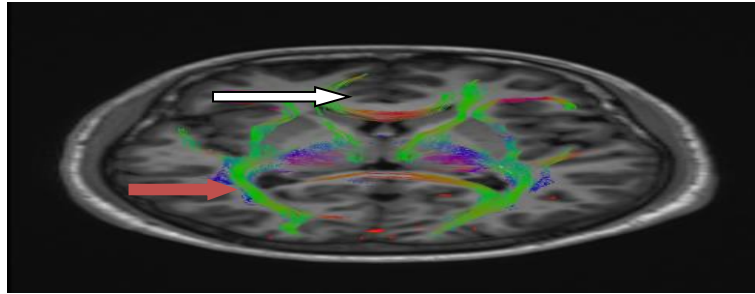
Axial MRI DTI images of the same patient at the level of internal capsule reveals normal fibers of internal capsule (White arrow) and optic radiation (red arrow).
